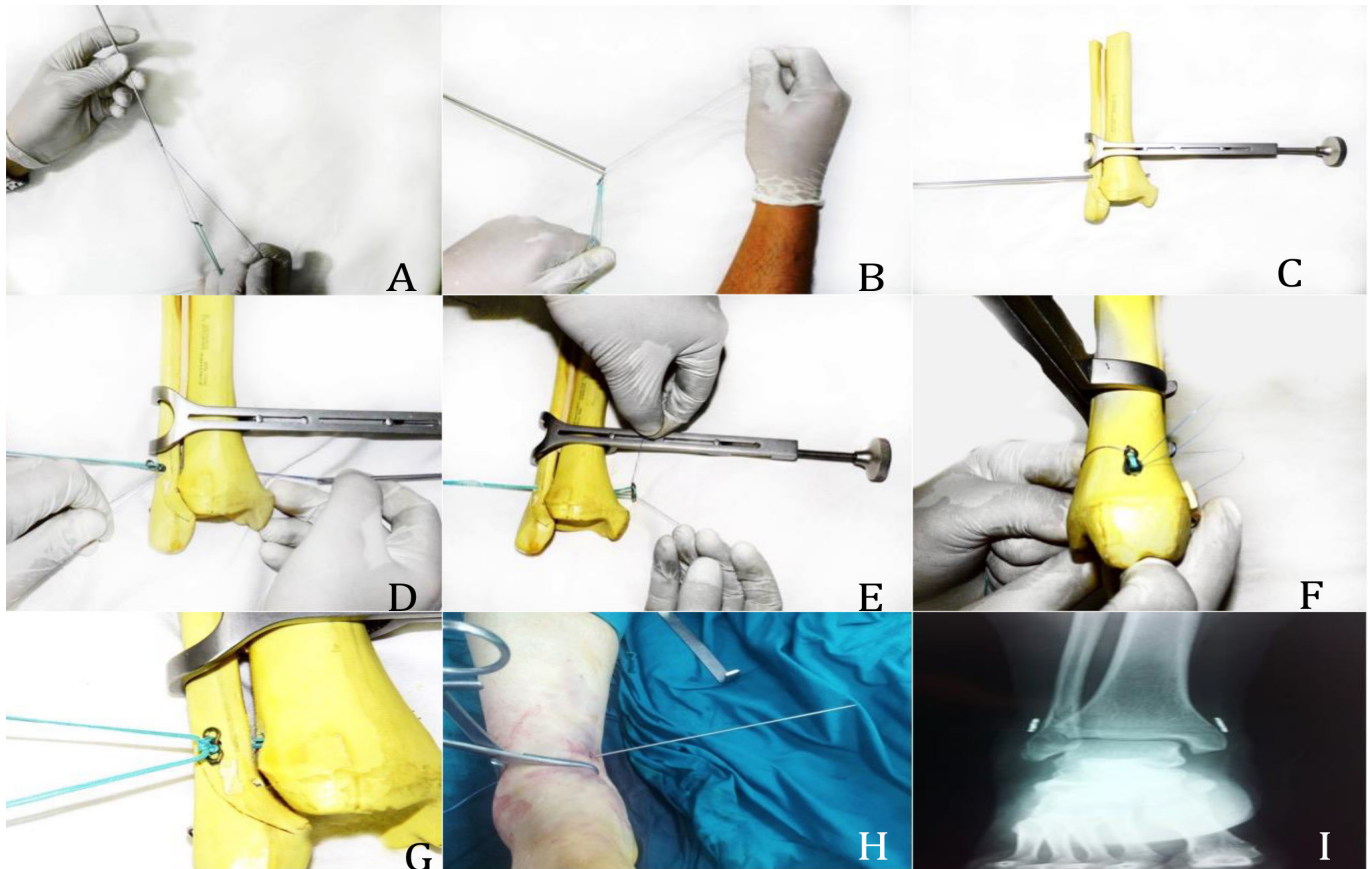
Surgical technique. 1A+B Sutures assembled onto the two hole plates. 1C- Drilling (4 mm) of the tibiofibular tunnel 2-5cm proximal to the joint line. 1D to 1F- passing of the tibia plate and ‘flipping’ it into position to anchor against the tibia. 1G- Fibula plate secured down to reduce the syndesmosis. 1H- Intra-operative images of the passing of the plate. 1I- Post-operative radiographs of the suture buttons in place and the syndesmosis reduced.
